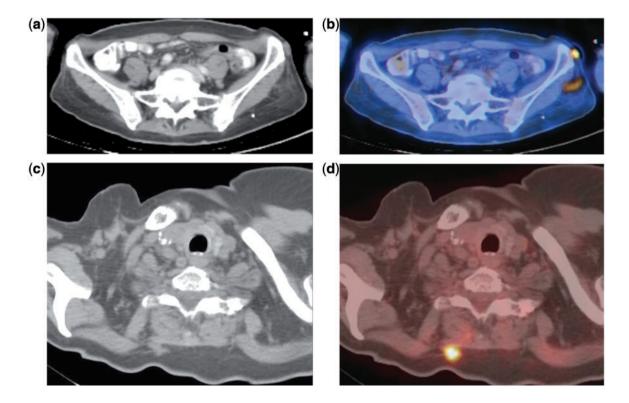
A 51-year-old woman with melanoma. (a, c) CT reveals subcutaneous nodules that could easily be overlooked. (b, d) Increased FDG uptake on PET directs the reader to these blind spots.
